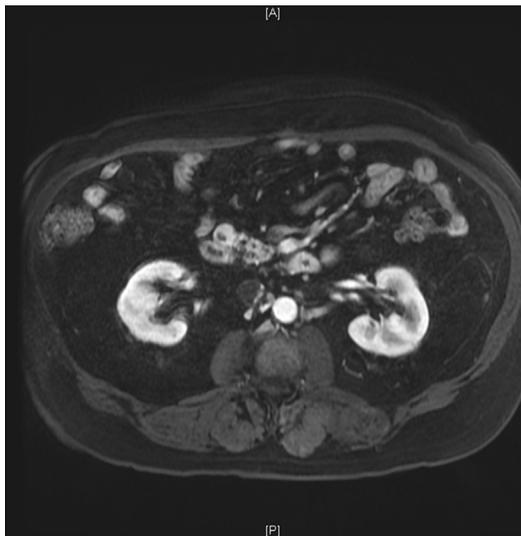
Select images from contrast-enhanced axial MR imaging demonstrating a hyperenhancing mass in the pancreatic head. Endoscopic ultrasound with aspiration was consistent with a pancreatic neuroendocrine tumor. Biochemical workup was negative. This PNET was managed with enucleation. Margins were negative. The patient recovered without complication and is 2 years post resection with no evidence of disease recurrence on follow-up axial imaging.
